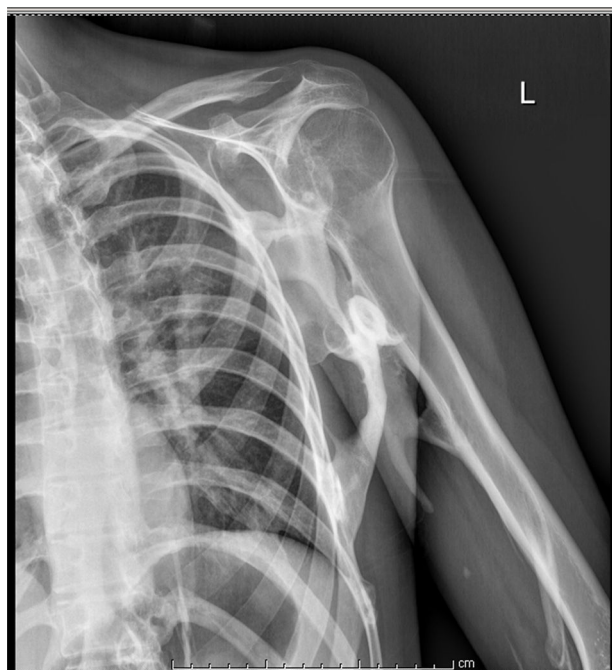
Radiograph of shoulder showing a well-defined plaque of mature bone between the chest wall, humerus and scapula.
